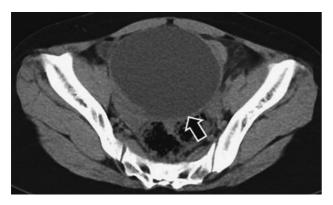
Abdominal contrast-enhanced computed tomography findings.
